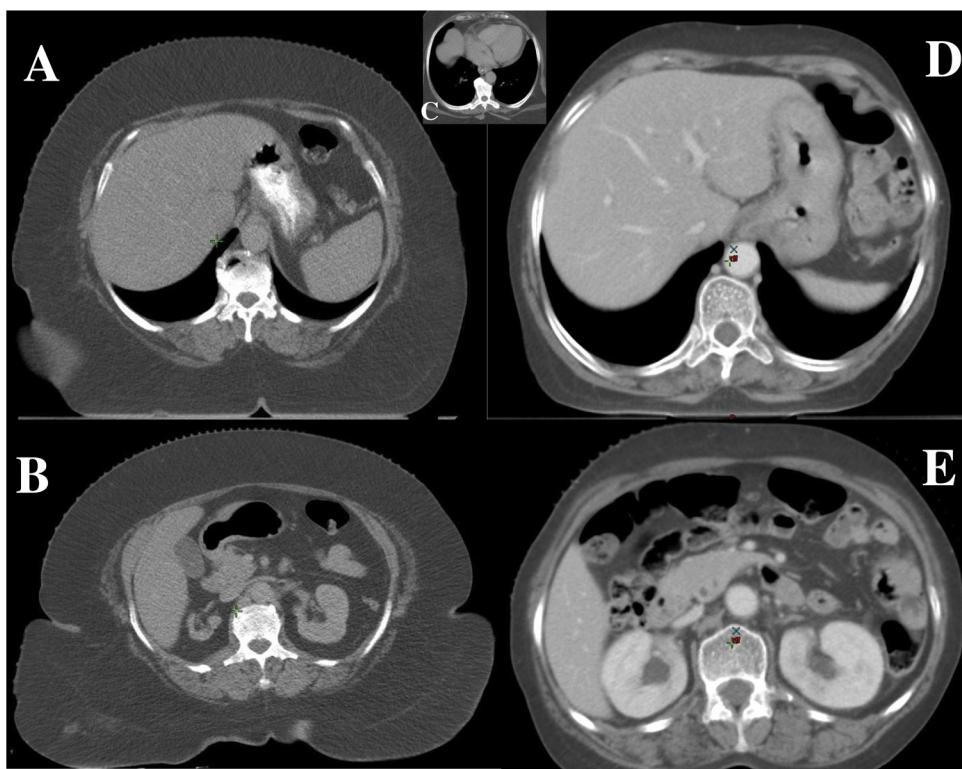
Comparison of axial CT image of morbid obese vs. the non-obese women with cancer. Gross multiple vertebral body degenerative / distortive changes, atrophy of liver, stomach, intestine, bilateral kidneys and pancreas noted in morbid obese patient compared to the corresponding CT image of same aged non-obese patient with cancer. (Fig. 2A, B, C are axial CT images of morbid obese patient. Remaining i.e. Fig. 2D, E are axial CT images of non-obese patients of same age).
